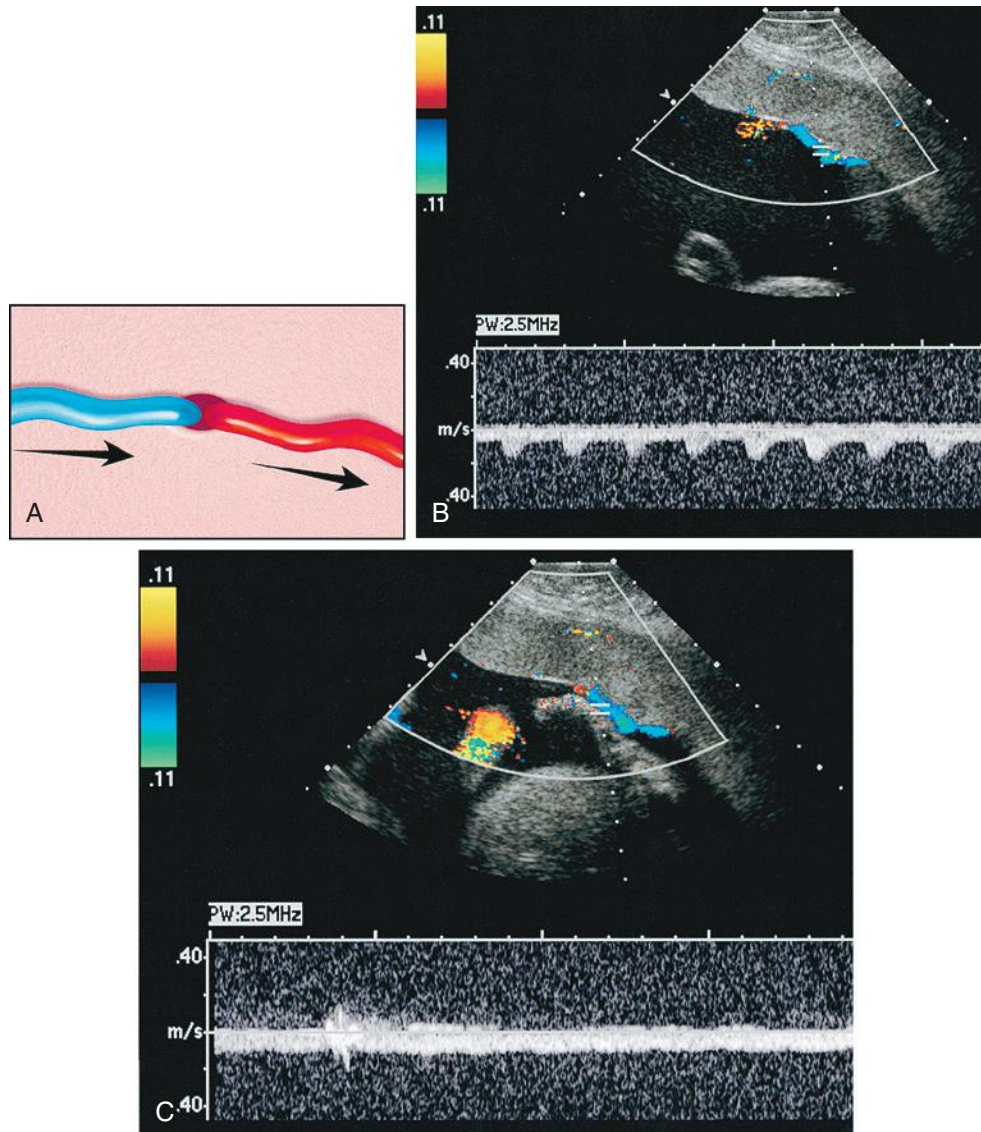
Color and pulsed Doppler of the surface-communicating vessels in monozygotic twins. A, Arteriovenous anastomosis in a monozygotic placenta. Overview from the fetal surface of the placenta shows feeding branch of umbilical artery from donor (*blue*) and draining branch of umbilical vein of recipient (*red*) entering the placenta via a common foramen. B and C, Color Doppler ultrasound study demonstrates an unpaired vascular structure on the placental surface. Spectral Doppler waveforms reveal a feeding arterial branch (in B) and draining venous branch (in C), with flow directed from the donor toward the recipient. D, Placental pathologic injection study showing an arteriovenous anastomosis (*arrow*) with donor-feeding arterial branch blue and recipient-draining venous branch red. E, Pulsed-wave color Doppler insonation of placental surface vessel showing the characteristic periodic bidirectional interference pattern of an arterio-arterial anastomosis. (A through C courtesy Vickie Feldstein, MD, University of California, San Francisco, School of Medicine, San Francisco, CA; D courtesy Geoffrey Machin, MD, Permanente Medical Group, Oakland, CA.)
